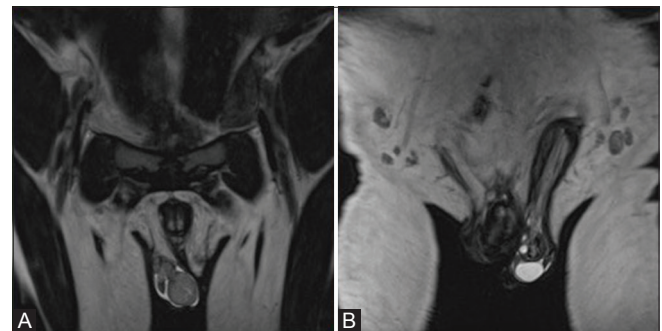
(A and B): (A) Coronal T2 weighted MRI pelvis shows testis in the right scrotal sac. (B) Coronal T2 weighted MRI pelvis shows left inguinal hernia with left ovary and non-functioning uterus
